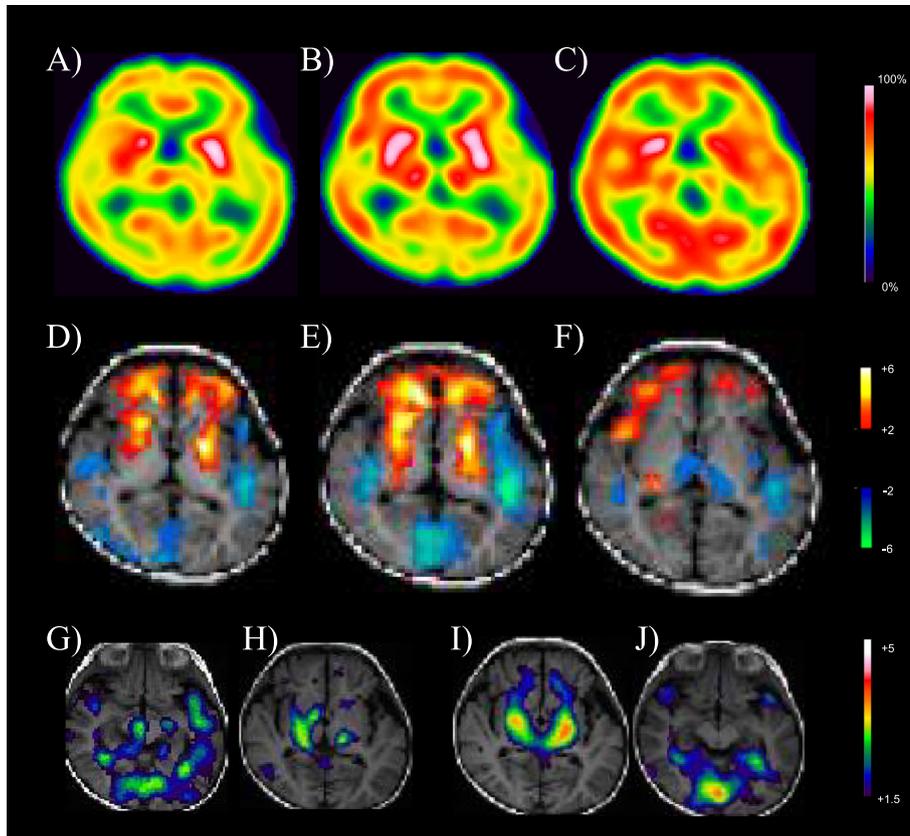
Serial SPECT imaging of cerebral blood flow (CBF). Original images of CBF, which are performed in the acute phase (A), in the subacute phase (B) and in the chronic phase (C), are shown. The statistical images (D–F) show eZIS data. The images showing abnormal CBF distribution are noted in the acute phase (D), in the subacute phase (E) and in the chronic phase (F). The Statistical images (G–J) show SISCOM data. The image (G) reveals the subtraction of the data in the subacute phase from that in acute phase; in the acute phase from in the subacute phase (H), in the subacute phase from chronic phase (I), in the chronic phase from subacute phase (J), respectively. These statistical images show progressive hyperperfusion in the frontal lobes, basal ganglia and thalamus, and hypoperfusion in the occipital and temporal lobes during the acute and subacute phases. The dynamic abnormalities in CBF improved, but hyperperfusion in the thalamus appeared in the chronic phase.
